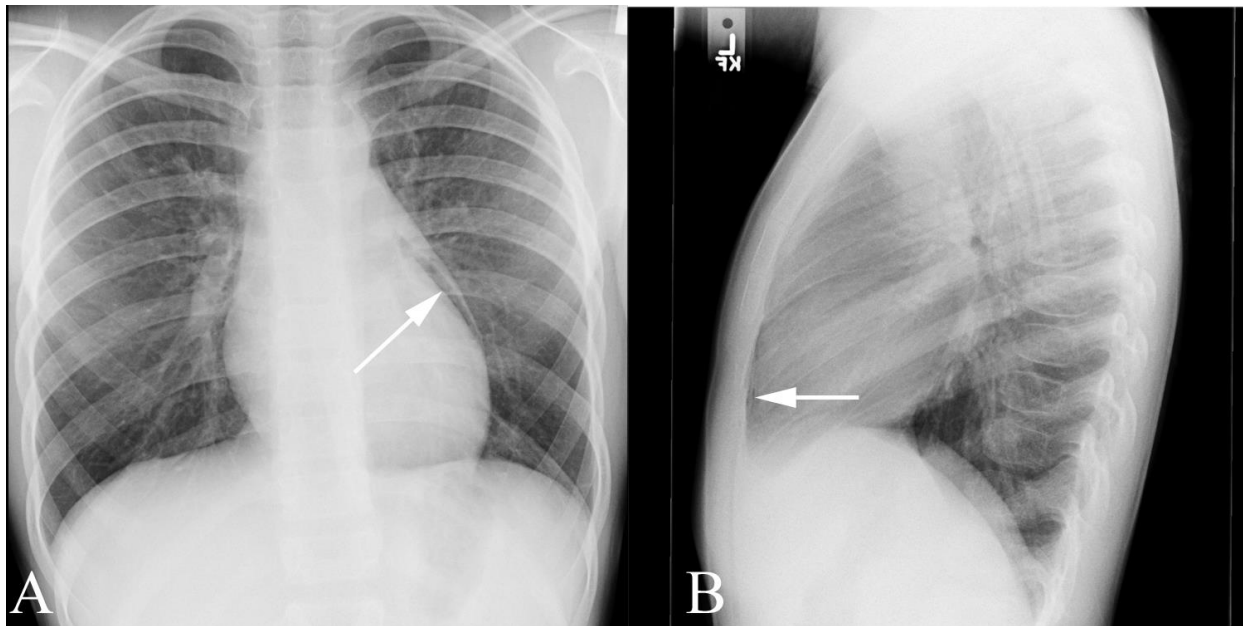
Pneumothorax in a 9 year old with asthma and cough. A. PA chest radiograph shows a lucency separating the normal thymus shadow from the heart border (arrow). B. Lateral chest radiograph shows a subtle lucency along the anterior chest wall (arrow) from pneumomediastinum.
